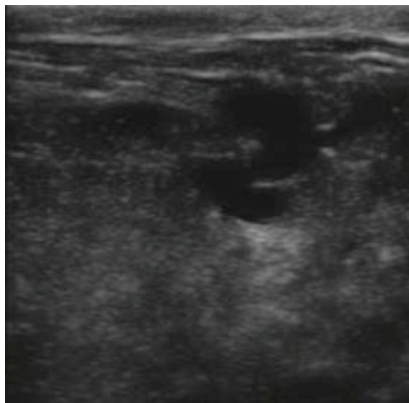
Normal udder sonogram
